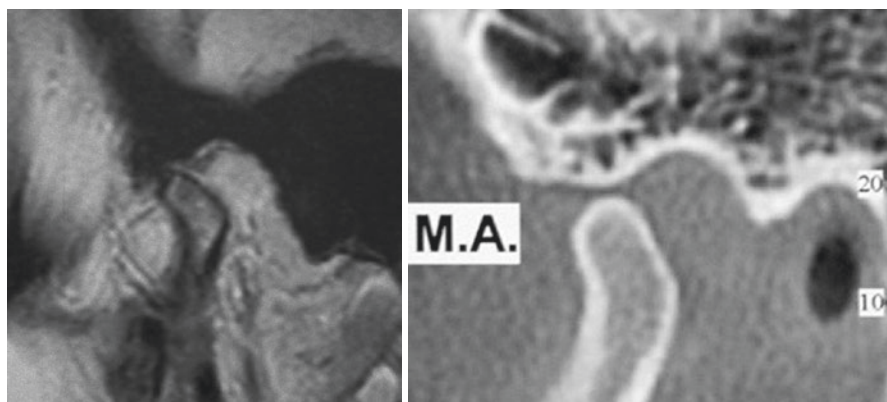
Parasagittal MRI scan and CT scan in the open mouth position 6 months after the arthroscopic procedure. Note the remodeled tubercle after the eminoplasty and the translation of the disc-condyle complex
